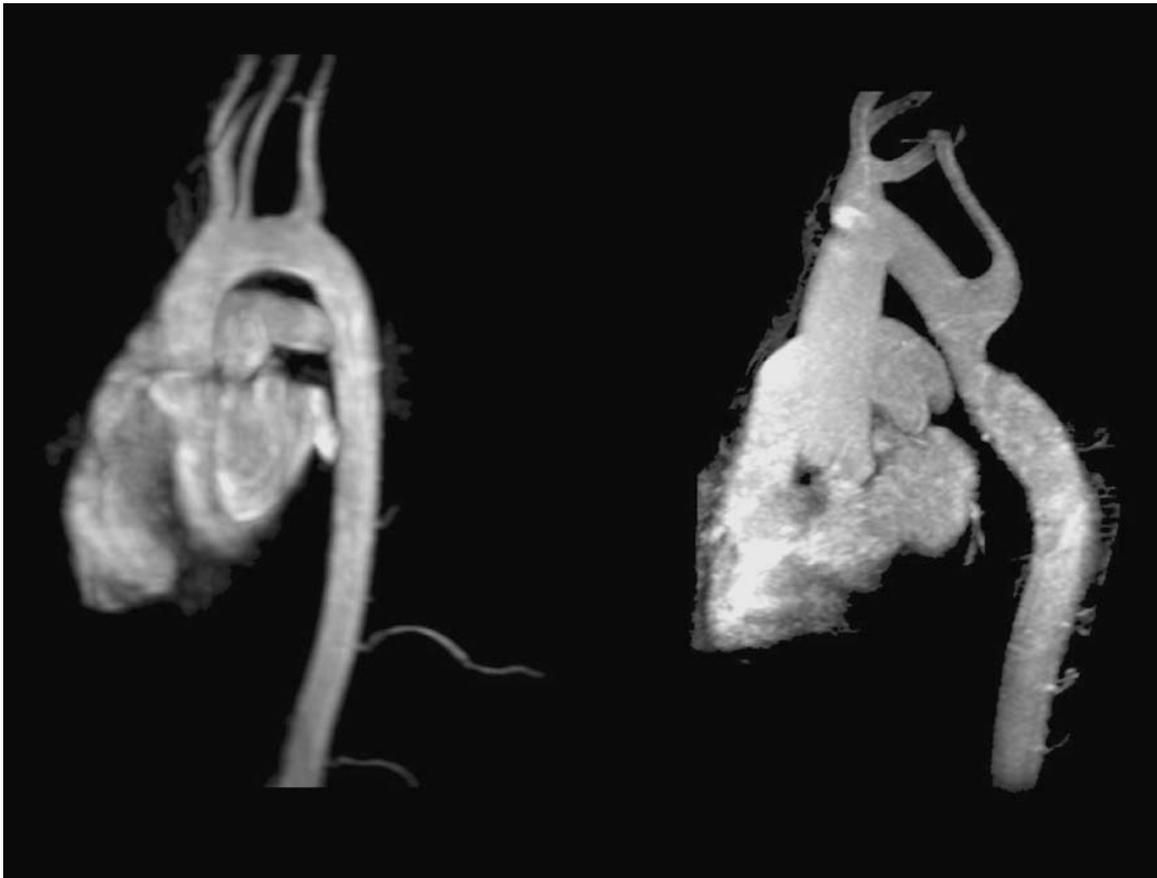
Magnetic resonance angiography in TS. The image on the left shows a normal aortic arch and major arteries. The image on the right shows an elongated, ectatic aortic arch with a coarctation just after the origin of the left subclavian artery, which is dilated. This coarctation was not detected on echocardiogram. Adapted from Ho et al. [33].
